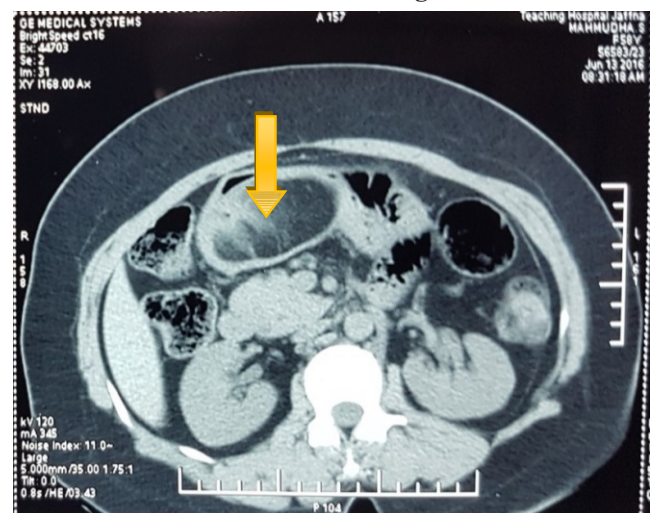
Computed Tomography picture of submucosal gastric lipoma
